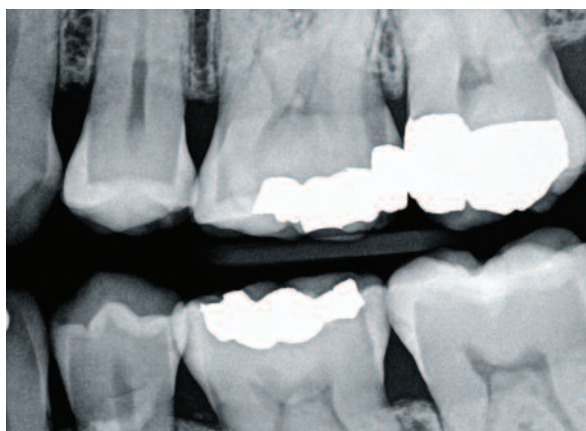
Preoperative radiographic evaluation revealed the depth of the preexisting restorations, with no periapical abscesses or other significant findings.
